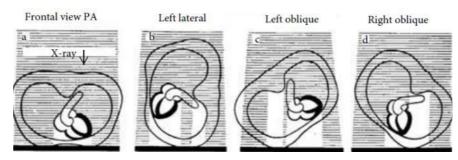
The position of the patient to the X-ray beam
